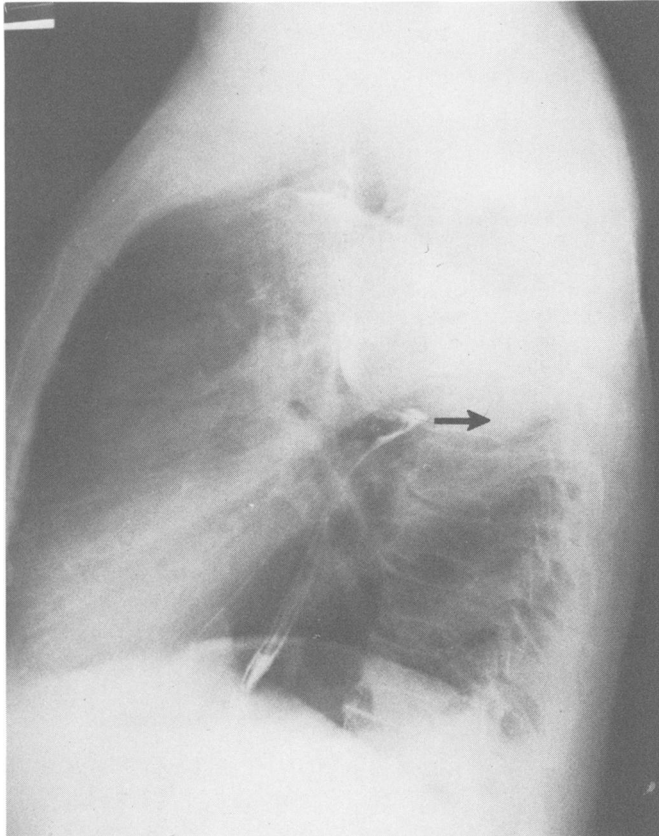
Roentgenogram of the esophagus in the same patient. The esophagus is flexed and displaced posteriorly with the aorta.
